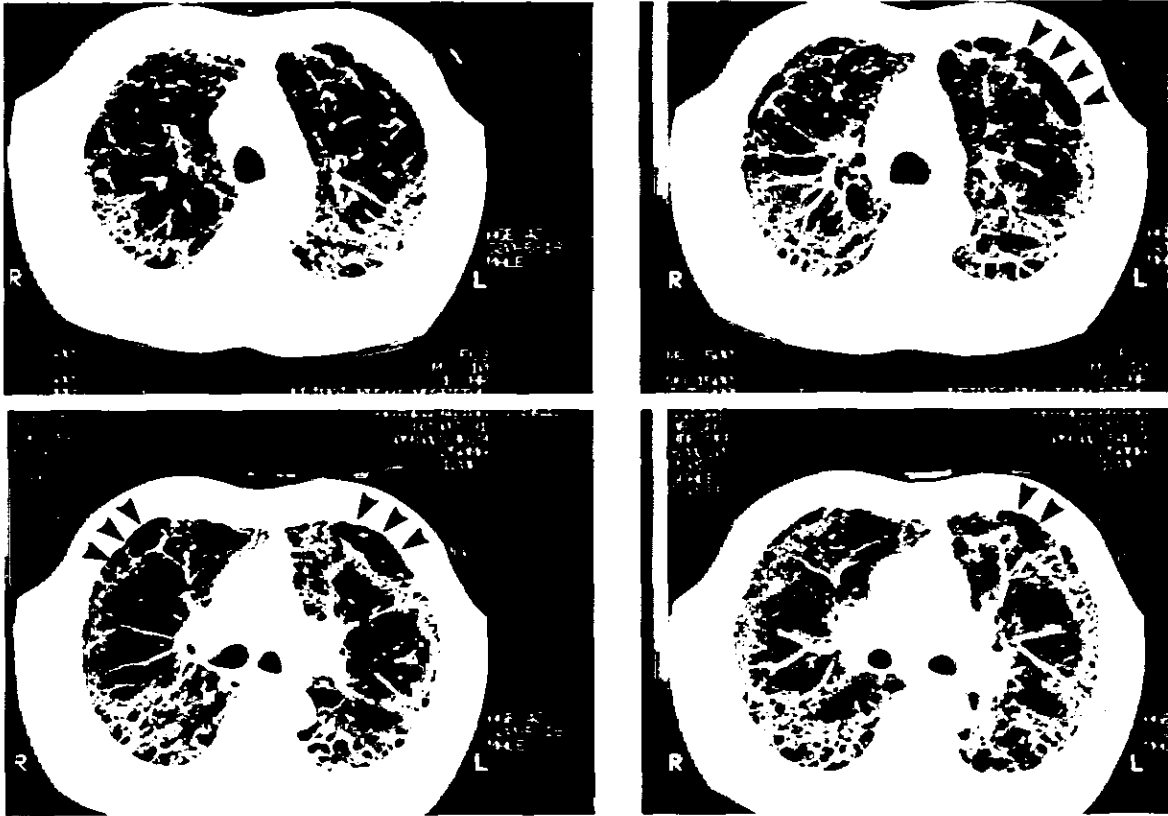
CT images demonstrate strand or streak like interstitial fibrosis associated with pulmonary emphysema, bullae (arrow) and honeycombing.
